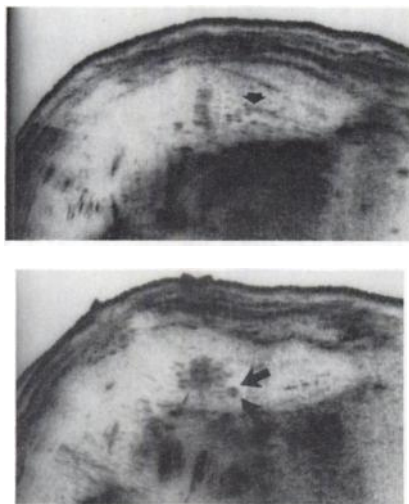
Ultrasonogram of biliary tree showing dilated duct (top, arrow) with calculus (bottom two arrows) in left lobe of liver.
